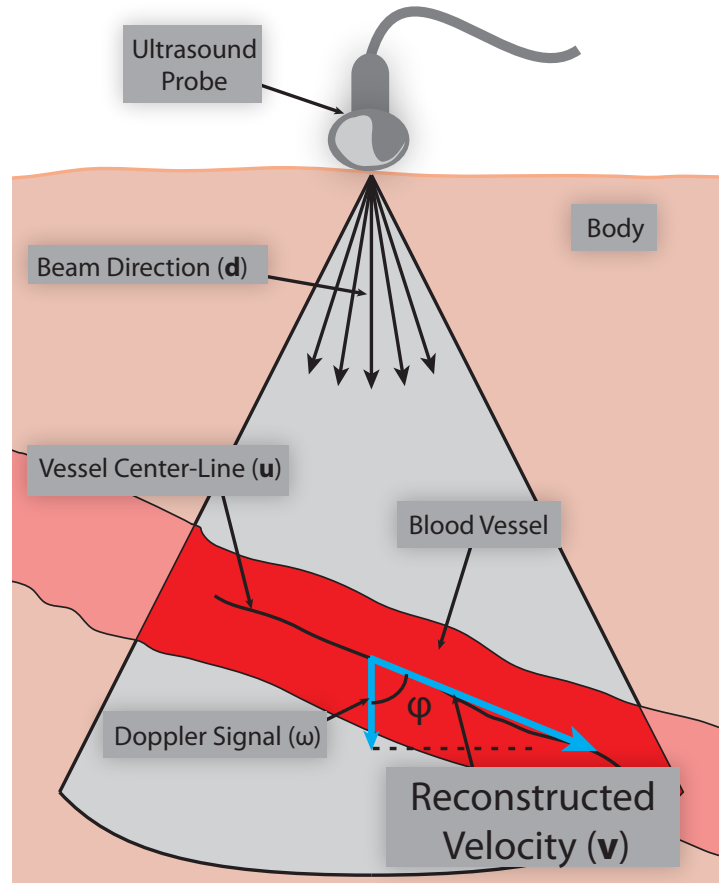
Reconstructing the actual velocity of the flow by projecting the measured velocity from the Doppler ultrasound onto the vessel direction.
